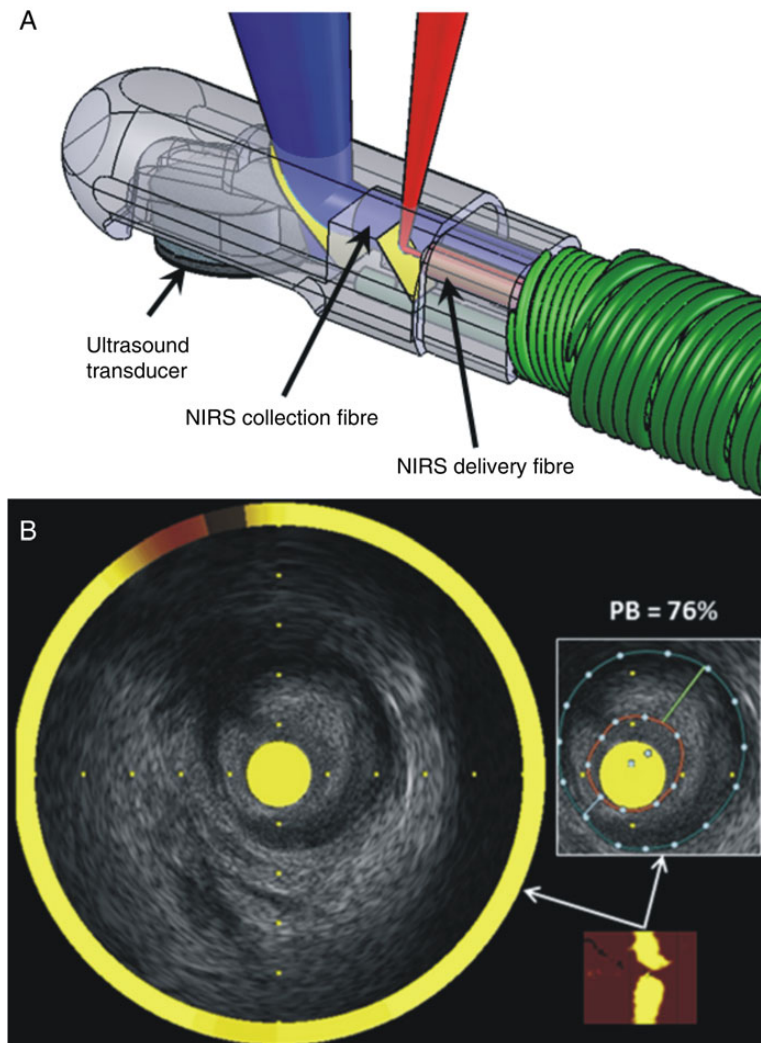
Combined near infrared spectroscopy—intravascular ultrasound catheter. (A) The tip of the catheter incorporates a rotating intravascular ultrasound transducer operating at 50 MHz with extended bandwidth, and two near infrared spectroscopy fibres that transmit and collect the near infrared light. (B) The chemogram is the output of the near infrared spectroscopy catheter (bottom right), is co-registered with the intravascular ultrasound data creating hybrid images that allow assessment of lumen, outer vessel wall, and plaque dimensions including plaque burden and simultaneous evaluation of the longitudinal and circumferential distribution of the lipid component. Panel B was reprinted with permission from Madder et al.³⁵
